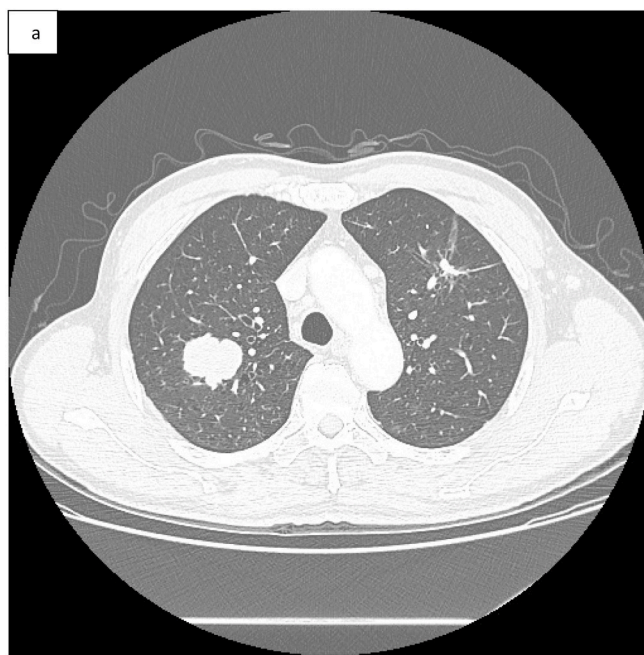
a/2b: Follow-up chest CT demonstrated that the LUL lung cancer had become smaller, but that the RUL tumor had become larger (2a); and the LUL/LLL part-solid GGOs had become mildly enlarged (2b).
